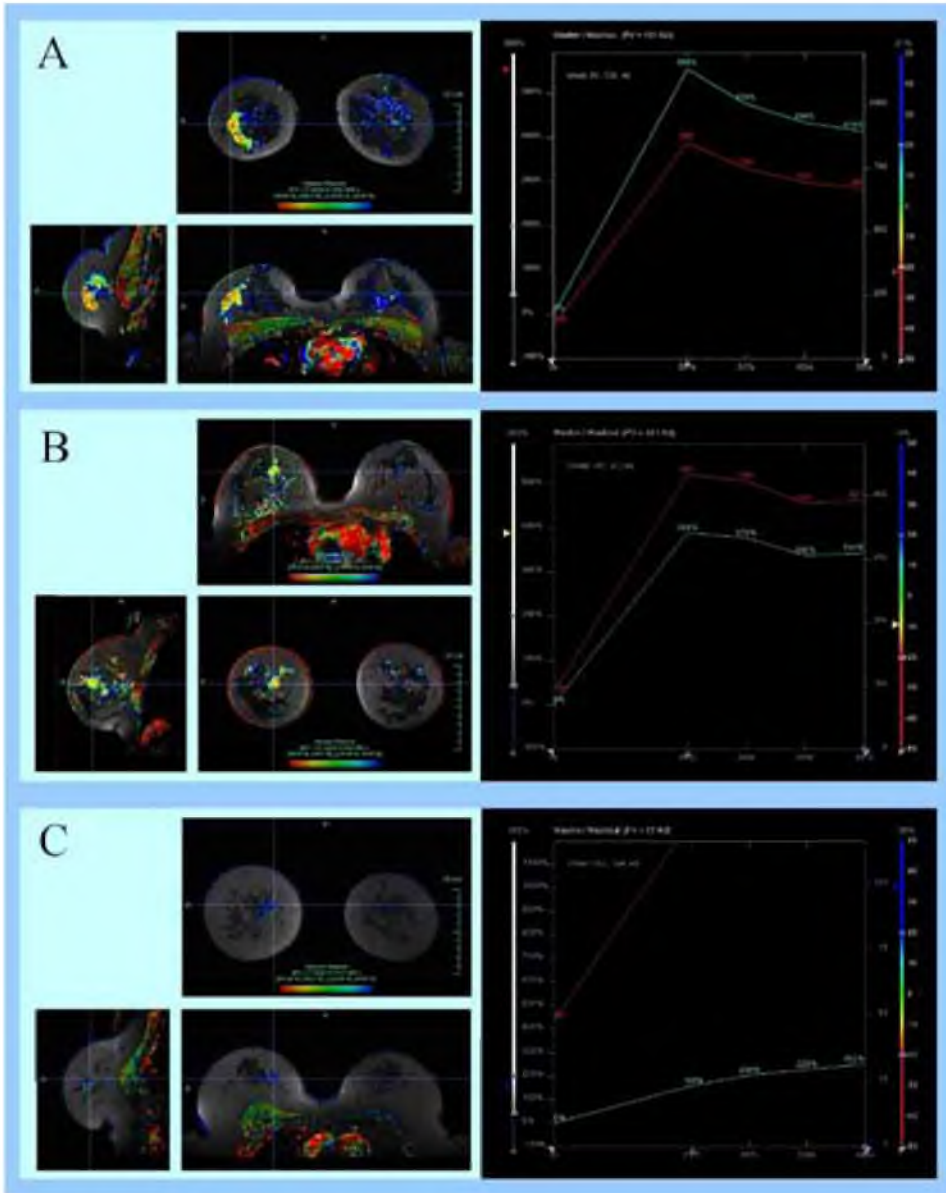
The dynamic profile of three different ILC. The colours within the tumour represent relative enhancement. Relative enhancement increases as colours change from blue through green and yellow to red. Tumour A is a very large ILC with a typical malignant enhancement pattern and a dynamic curve showing rapid initial enhancement and subsequent wash-out of the contrast agent. Tumour B shows a less malignant pattern with a plateau phase in the dynamic curve after initial rapid enhancement. Tumour C shows no rapid enhancement and no subsequent wash-out. Although the tumour is readily visible on MRI it may thus be reported as enhancing breast tissue because the typical malignant pattern is absent.
